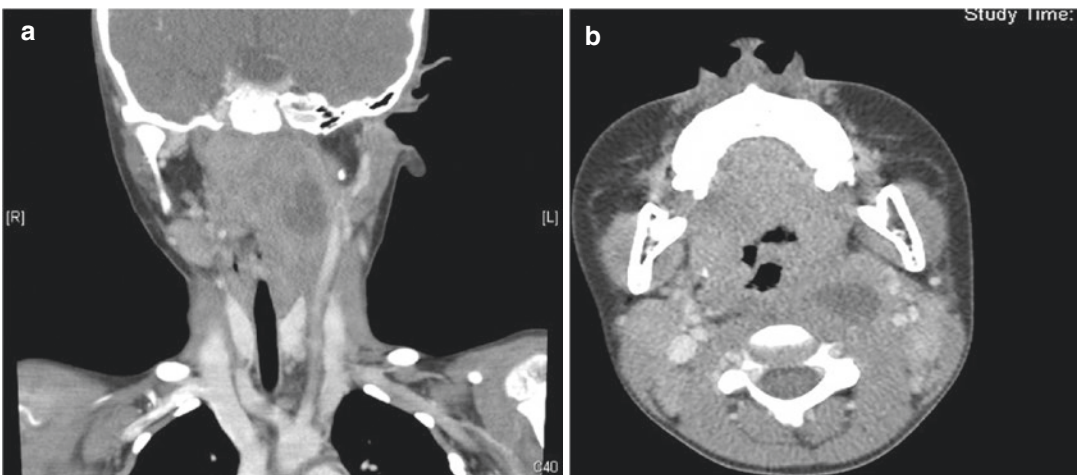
Head and neck CT scan showed cervical lymphadenitis, bilateral with abscess formation at left side retropharyngeal region of naso- and oropharynx level in coronal plane (a) and axial plane (b)
